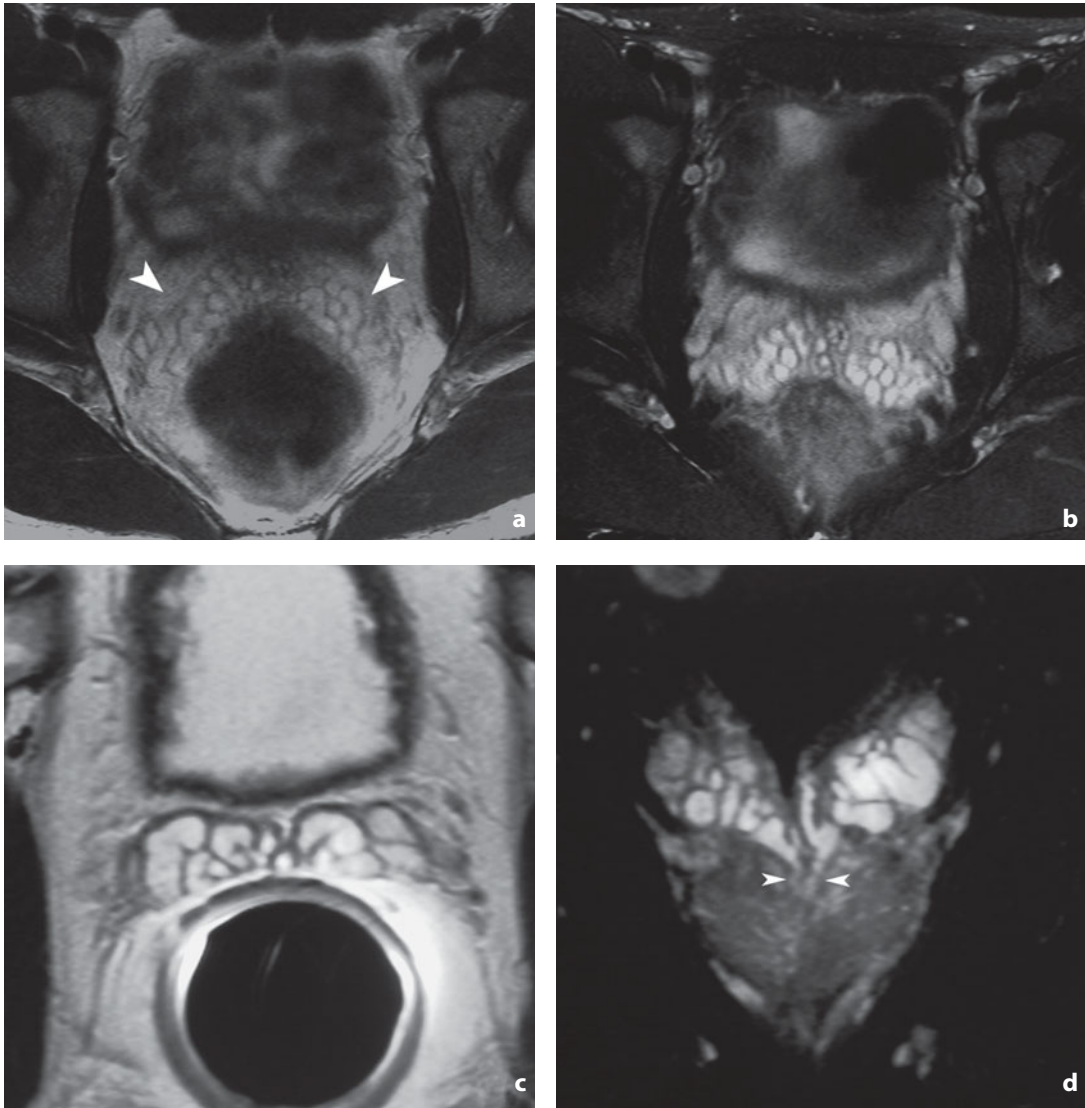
Magnetic resonance. Seminal vesicles. a,b Adolescent subject. T2-weighted image without (a) and with (b) fat signal suppression. Typical honeycomb appearance of the vesicles (*arrowheads*). c,d Adult. T2-weighted axial (c) and coronal (d) images. The latter clearly depicts the ejaculatory ducts (*arrowheads*)
